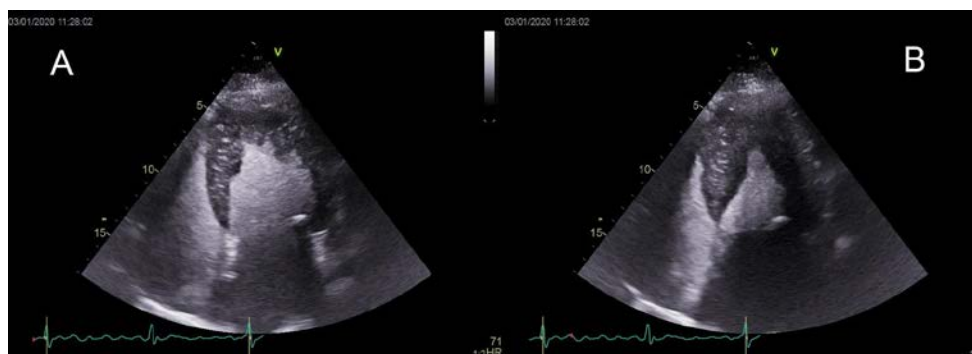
Contrast echocardiographic finding of newly diagnosed apical hypertrophic cardiomyopathy.
